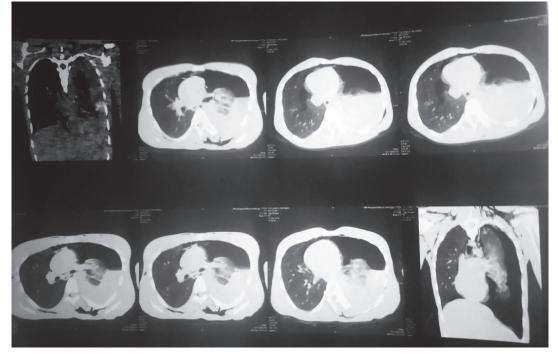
Multisliced computed tomography (MSCT) of the thorax at the time of admission.
